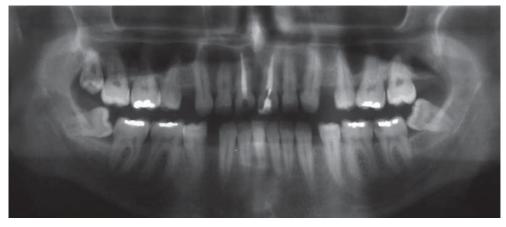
Panoramic radiograph after 8 month of the follow-up. The patient is free-diseases.
